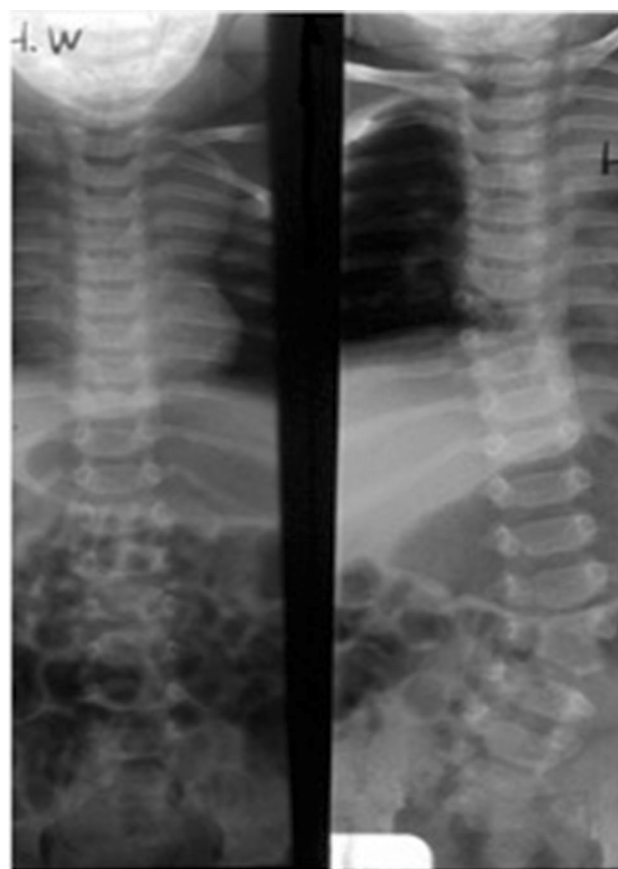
AP plain film X-rays of twin A (left) and twin B (right) demonstrating left T9 hemivertebra and fused right L4 hemivertebra in the affect twin B and normal spine in unaffected twin A
